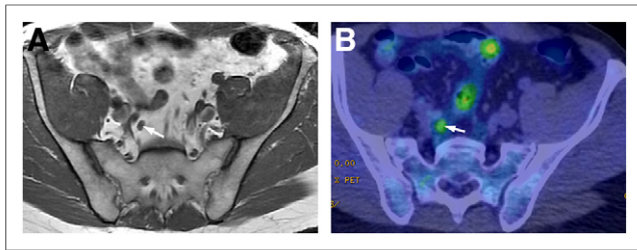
A 54-y-old man with PSA level of 2.7 ng/mL, who underwent RP 2.5 y earlier and then received salvage external-beam radiotherapy. Results for discordant false-negative MR imaging and true-positive ^{11}C -choline PET/CT with a score for MR imaging of 3 and a score for ^{11}C -choline PET/CT of 5 for LN metastasis are shown. (A) Axial T1-weighted MR image shows 5 × 7 mm right internal iliac LN (arrow). (B) ^{11}C -choline PET/CT image at corresponding level demonstrates choline-avid right internal iliac LN (arrow) with SUVmax of 3.8.
